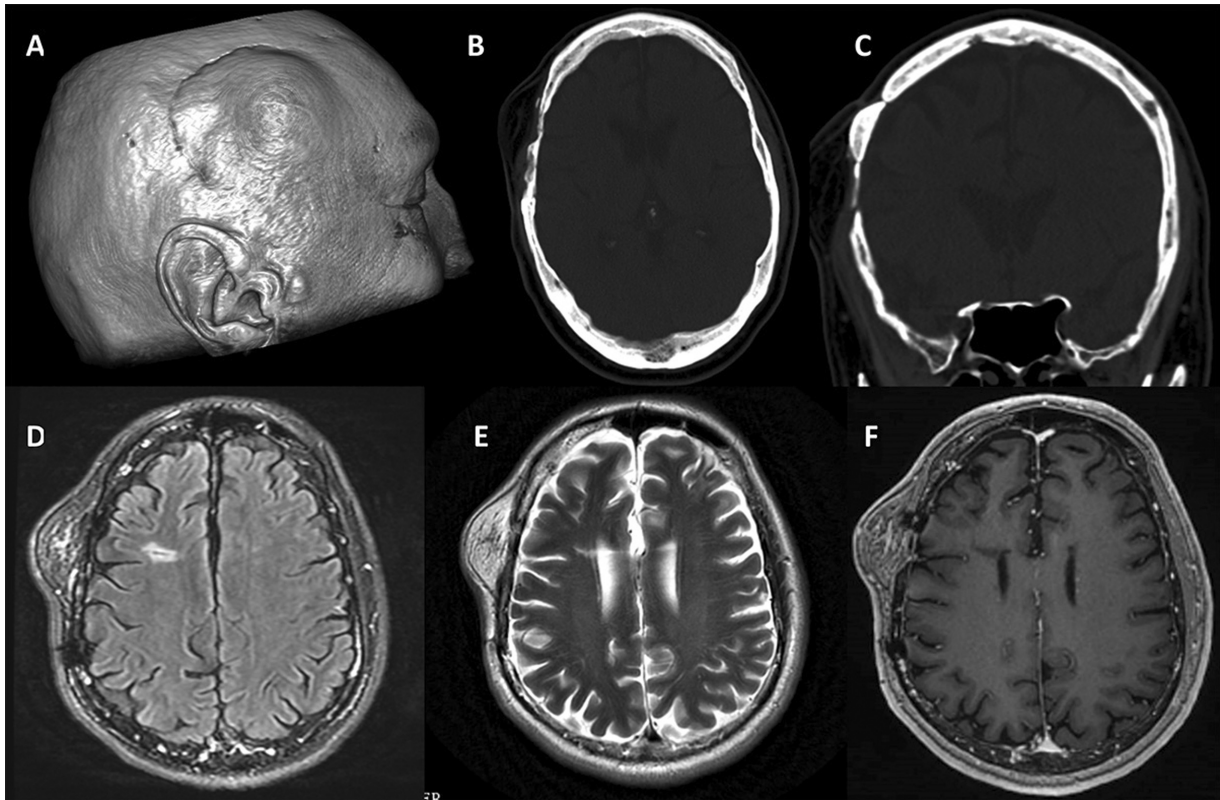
(A) 3D rendering from MRI head showing the location of this R frontoparietal soft tissue mass. (B, C) Axial and coronal CT images in bone window showing prior craniectomy with a well healed bone flap. A small osseous overgrowth is also noted on the superior aspect of the bone flap. (D–F) Show the T2 FLAIR, T2 and T1 postcontrast images respectively of the fatty mass with multiple internal septations. 3D, three-dimensional; CT, computed tomography; FLAIR, fluid-attenuated inversion recovery; MRI, magnetic resonance imaging.
